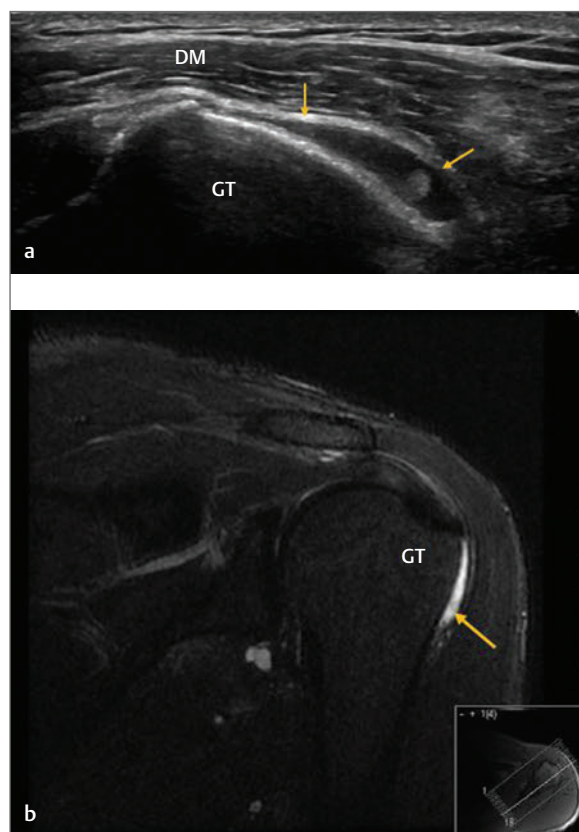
(a) Longitudinal image of the greater tuberosity. The subacromial bursa is seen to be distended (yellow arrows) as it overlays the lateral aspect of the greater tuberosity (GT). (b) MRI (coronal STIR). The image is of the same shoulder as in part (a). The image demonstrates high signal in the subacromial bursa (yellow arrow). DM, deltoid muscle.
